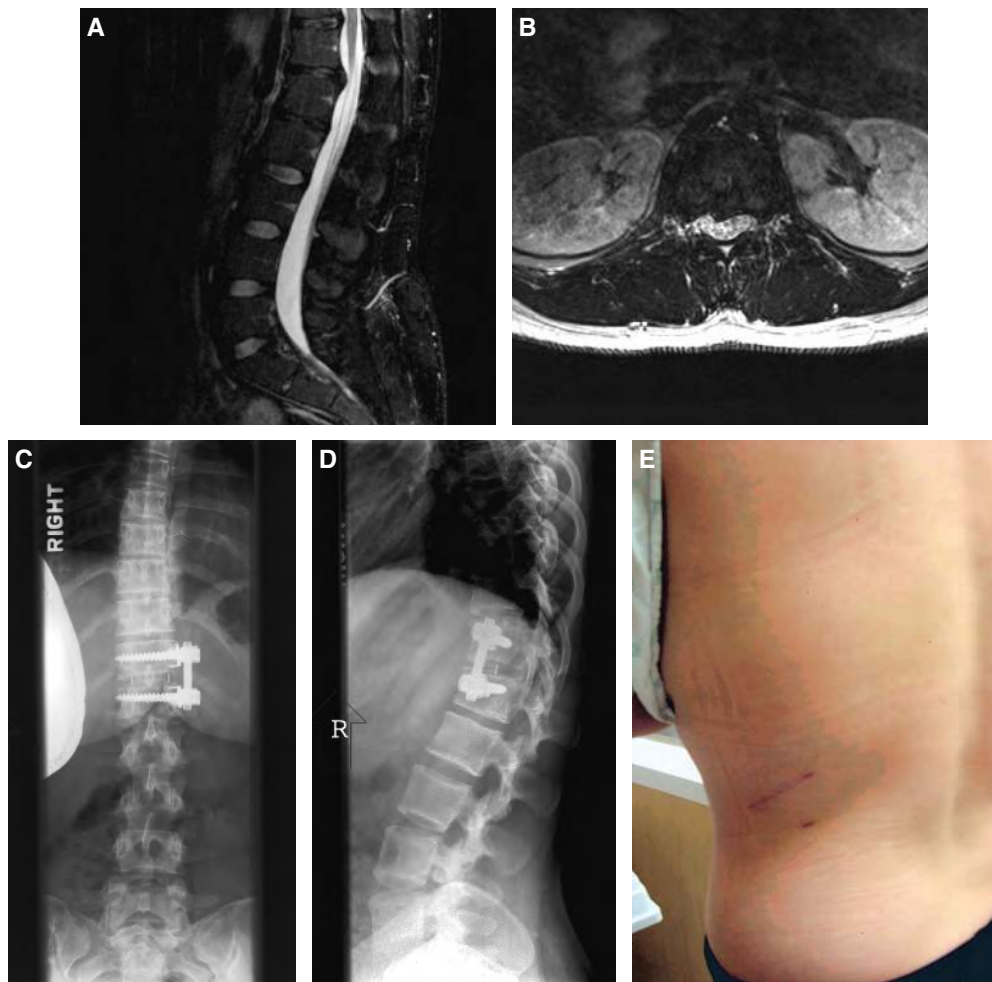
A*, Sagittal and *B*, axial T2-weighted MRI of a 20-year-old woman who presented with worsening bilateral lower extremity pain, urinary retention, and fecal incontinence. The MRI demonstrates a T12-L1 central disc herniation. *C*, Anteroposterior and *D*, lateral radiographs of this patient after treatment with thoracic disc excision and interbody fusion with lateral instrumentation. *E*, The minimal postoperative scar 1 month after the procedure.
